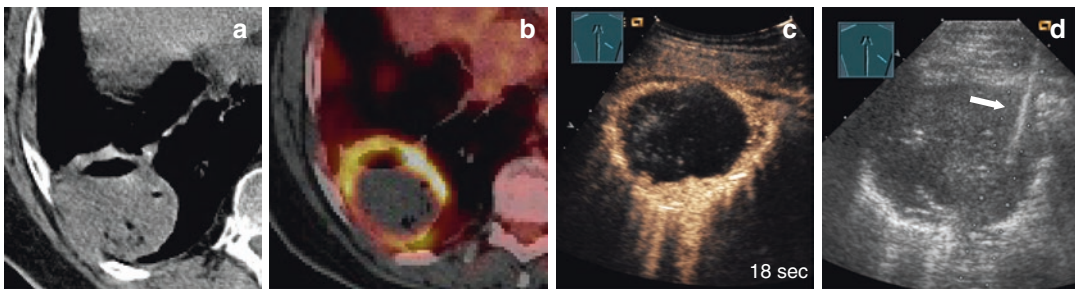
Patient with suspected pleural empyema on CT scan (a); B-mode imaging presents a pleural-based oval lesion (b); CEUS shows a strong border enhancement with central no enhancement characteristic for *pleural empyema* (c); US-guided catheter drainage was performed (arrow) (d), and correct position was confirmed by extravasal transcatheteral application of contrast medium (e)
